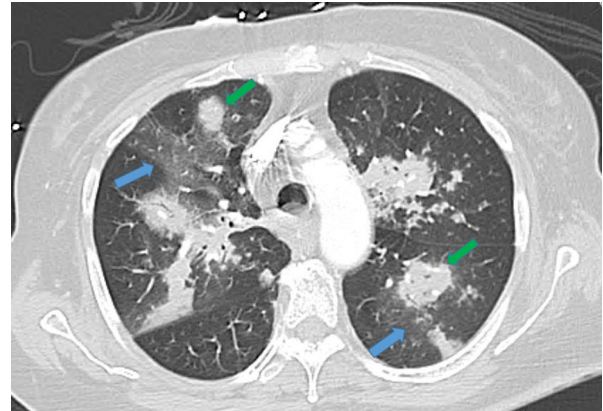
High-resolution computed tomographic scan of the chest revealing multiple foci of ground glass opacities (blue arrows) and bilateral pulmonary nodular infiltrates (green arrows).
